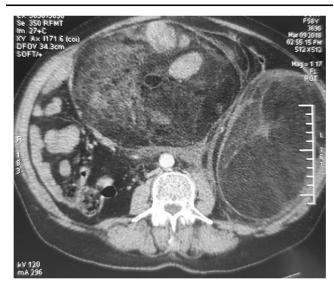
Computed tomography images showing the tumors their boundaries and extensions.
